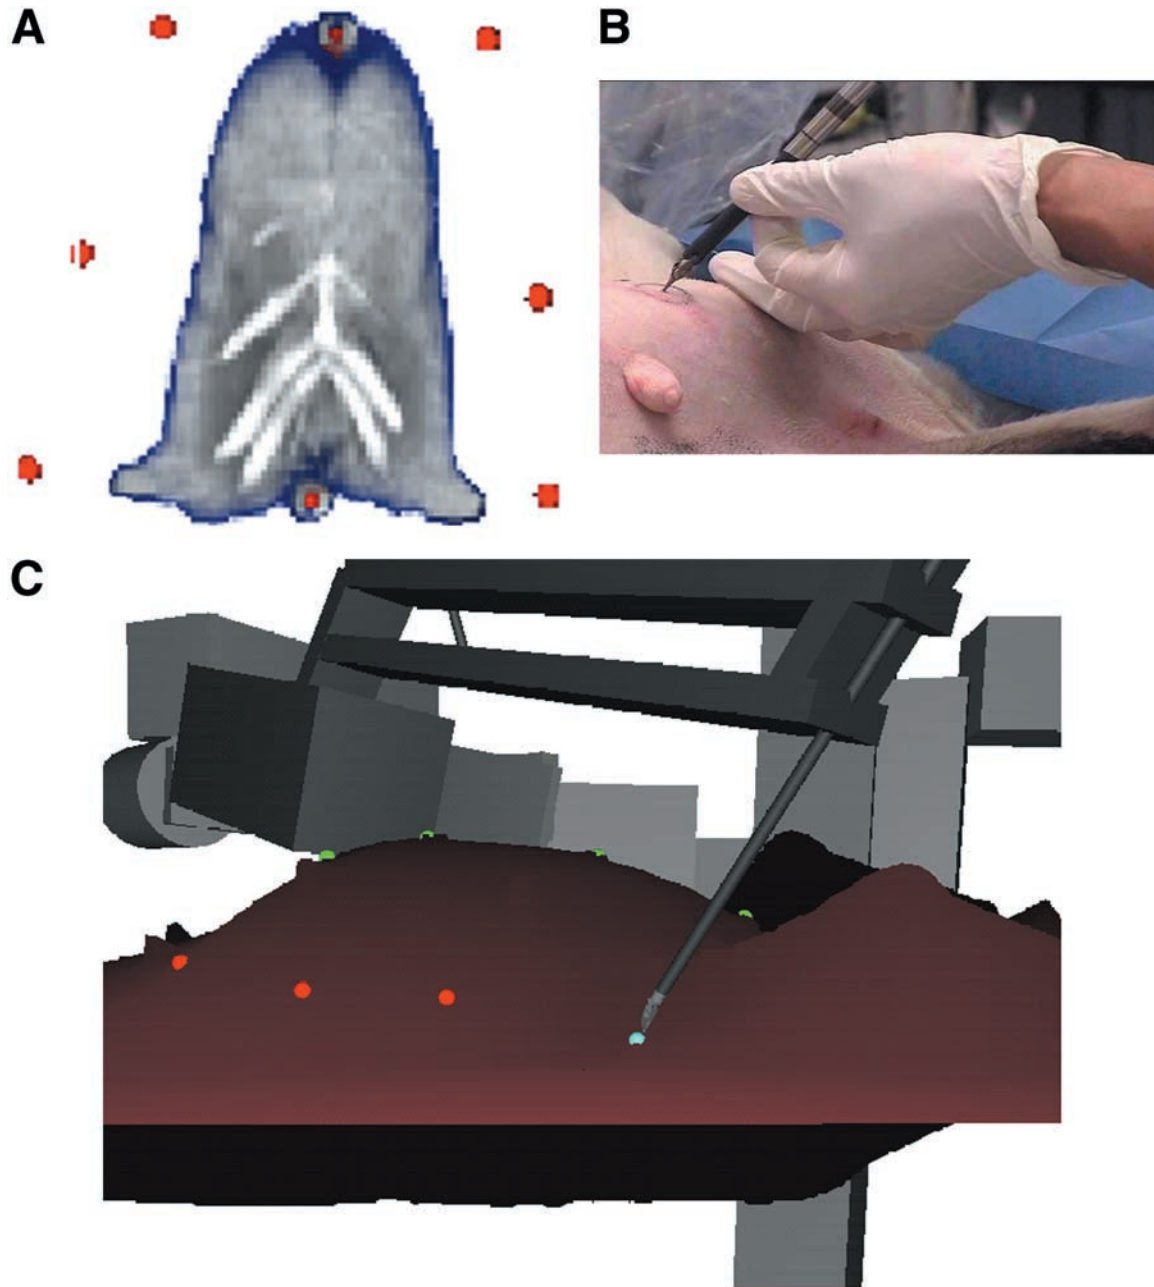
Fiducial markers are easily distinguished in preoperative CT images (A). Pointing fiducial markers with the robot tool tip (B and C).
